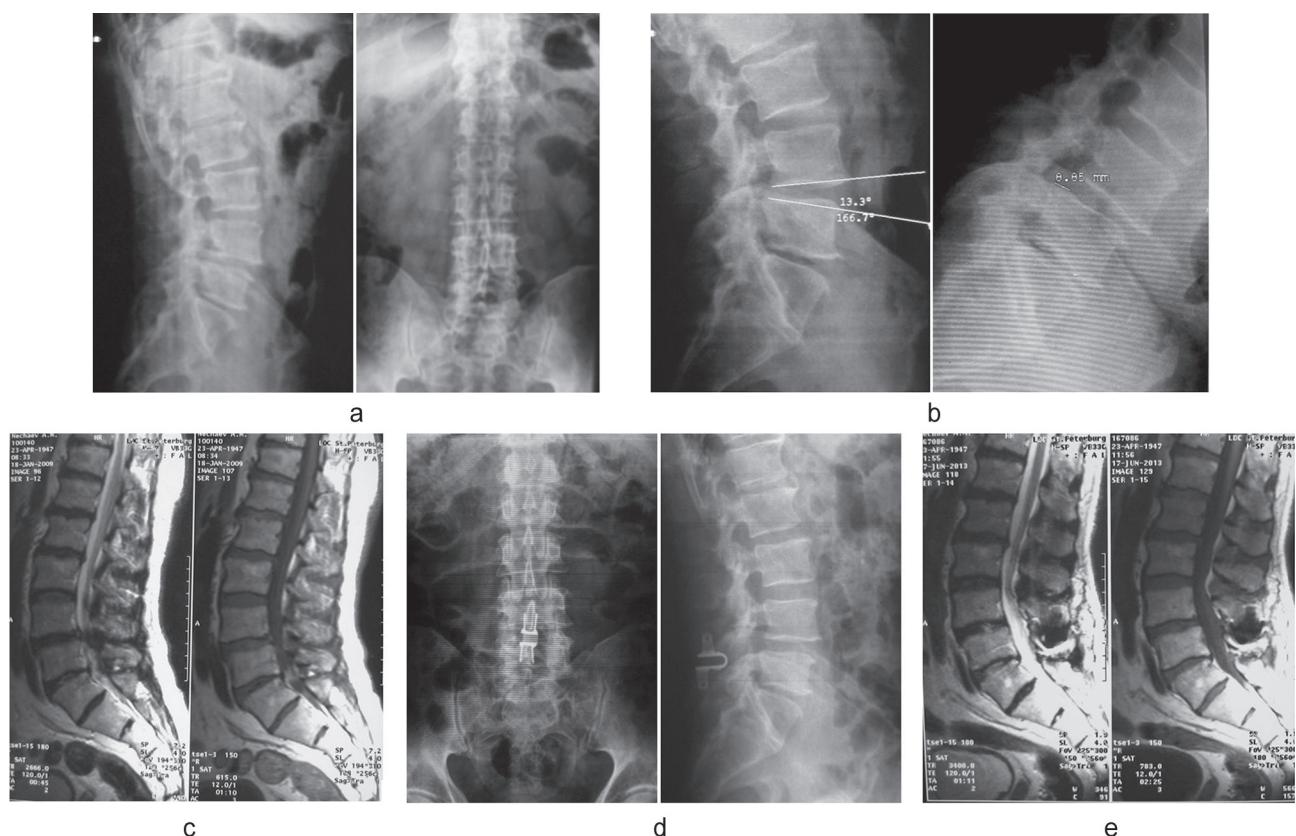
Radiographs and MRI images of the spine of a 62-year-old male patient N. with spinal stenosis at L4-L5 level, grade I degenerative spondylolisthesis of L4 vertebra showing (a) preoperative AP and lateral views, (b) functional radiography, (c) preoperative MRI image of lumbar spine, (d) postoperative AP and lateral views of lumbar spine, (e) MRI image of lumbar spine at 4 years after the surgery
